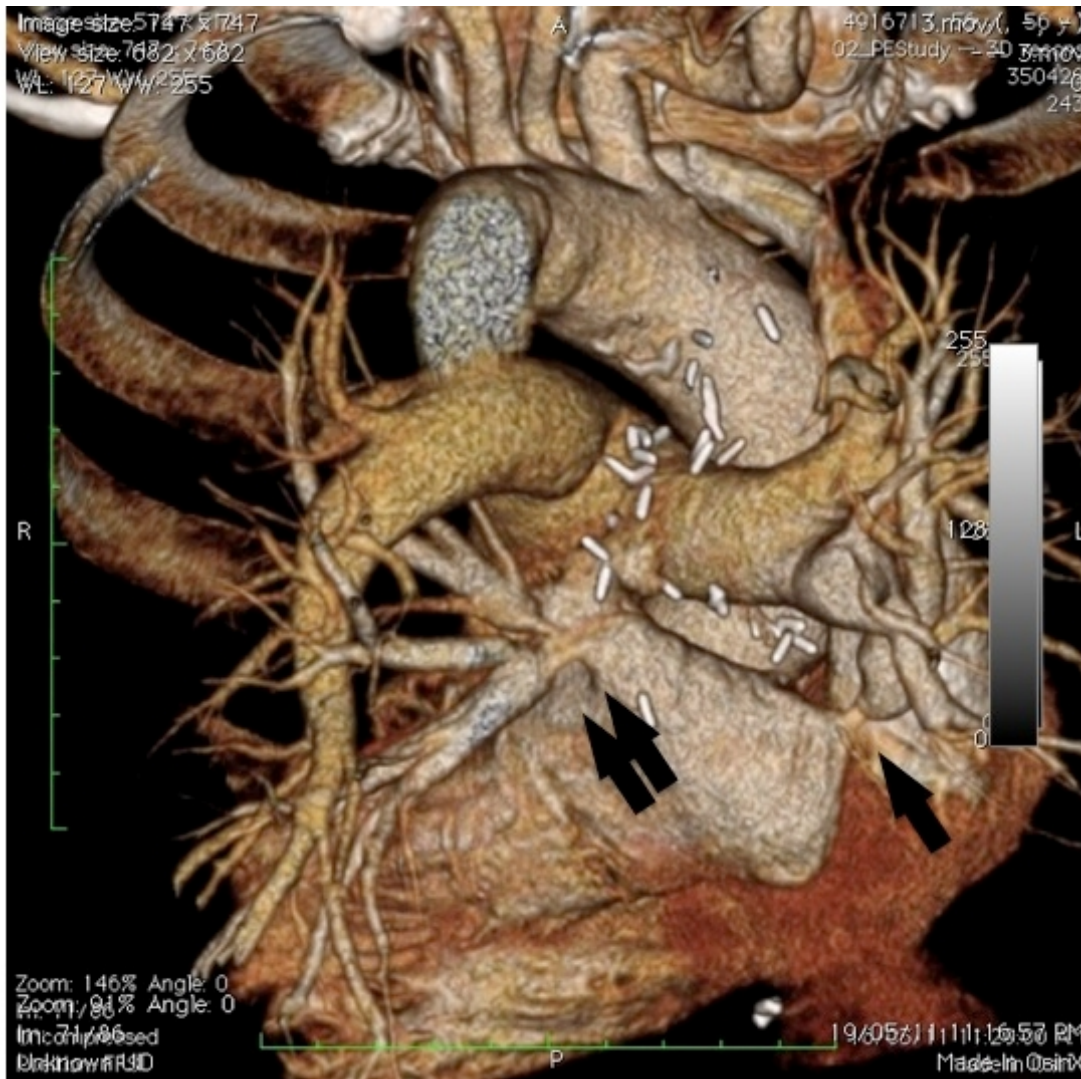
Three-dimensional reconstruction from computed tomography pulmonary angiography showed the discrete stenosis at the single right superior pulmonary vein (solid arrow) and the confluence of the left superior and inferior pulmonary veins (double arrows)
